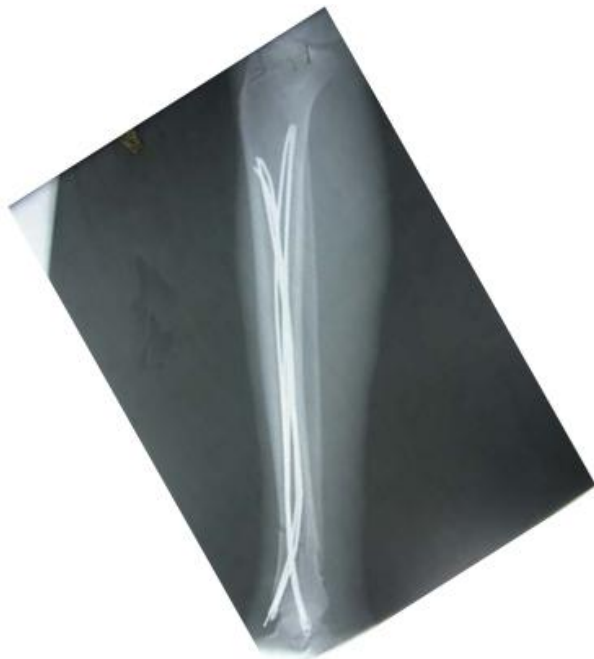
Pre Op Xray(AP view)
